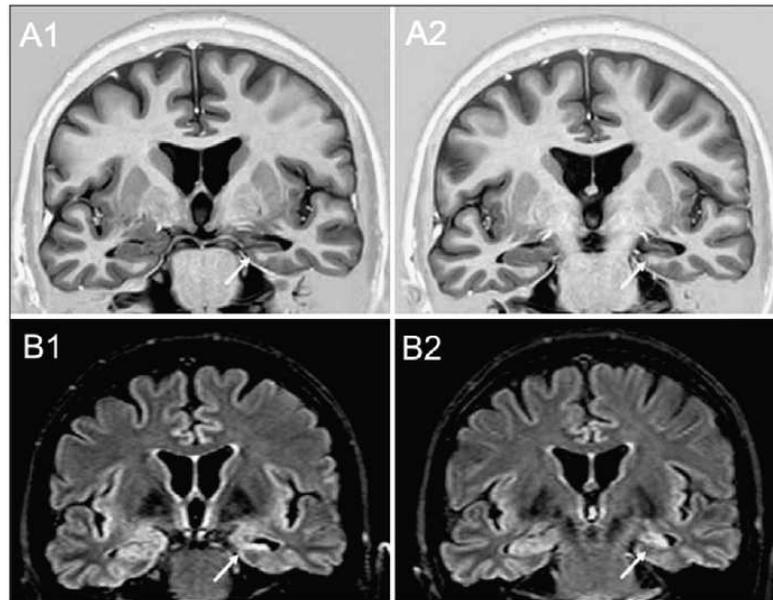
3-Tesla MRI coronal T1-weighted inversion recovery (A1 and A2) and T2-FLAIR (fluid-attenuated inversion recovery) images (B1 and B2) from a patient with left mesial TLE showing signs of left hippocampal sclerosis (arrows): hippocampal atrophy with abnormal shape and hyperintense signal on T2-FLAIR images.
